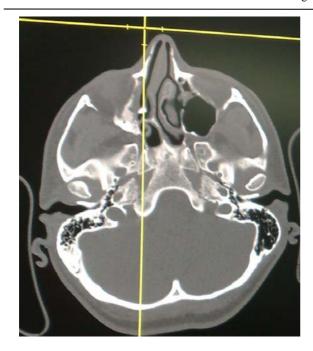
CT scan: A "tooth like" element in the right nasal cavity at the level of the middle turbinate
